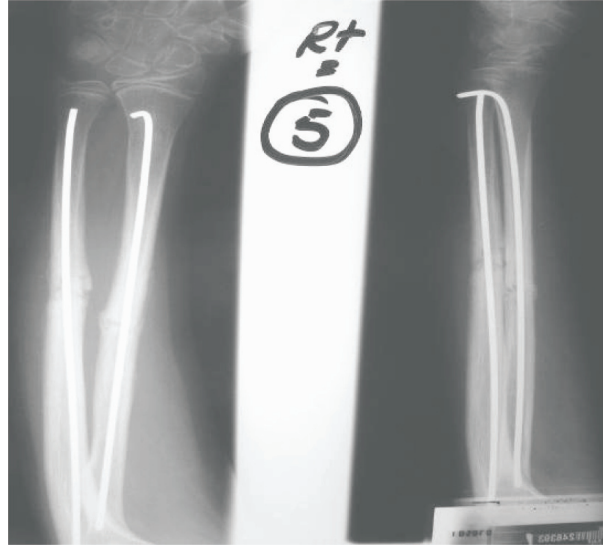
(Case 1) Post operative X-ray showing intramedullary K wires in situ
